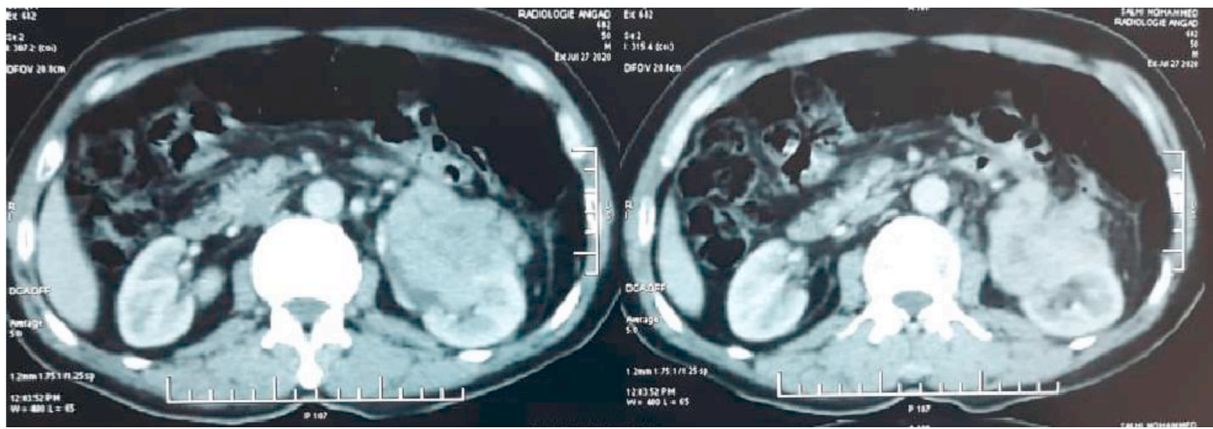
Axial contrast enhanced CT image through the abdomen shows left renal mass which is contrasting heterogeneously.
